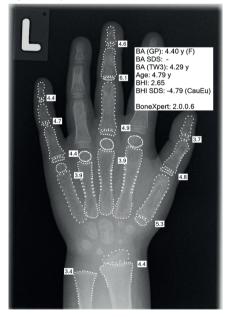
Example of hand radiograph analyzed with the BoneXpert software
